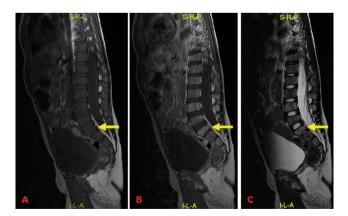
On sagittal T1-weighted images (A) there is diffuse abnormal hypointense bone marrow with multiple mild compression fractures of superior endplate involving D8, D9, D12, L1 and, particularly S1. After administration of paramagnetic contrast (B) there is patchy enhancement of the bone marrow more evident at S1 and L4 levels. The sagittal T2-weighted images (C) show heterogeneous bone marrow signal involving S1 and L4. Findings were possibly related to post-traumatic alteration or pathologic replacement of the bone
